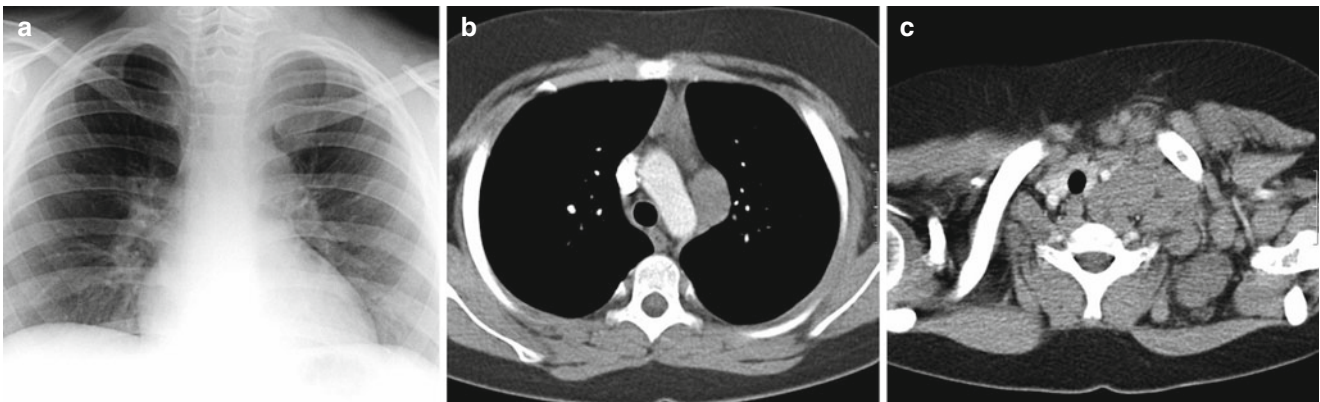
Nodular sclerosing Hodgkin's disease. (a) Chest radiograph showing increased soft tissue in the left mediastinum in the region of the aortic knuckle. (b) CT confirms tumor lateral to the aortic arch
